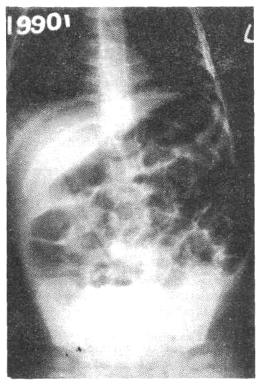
lb. Roentgenogram showing bulging on the left side.
